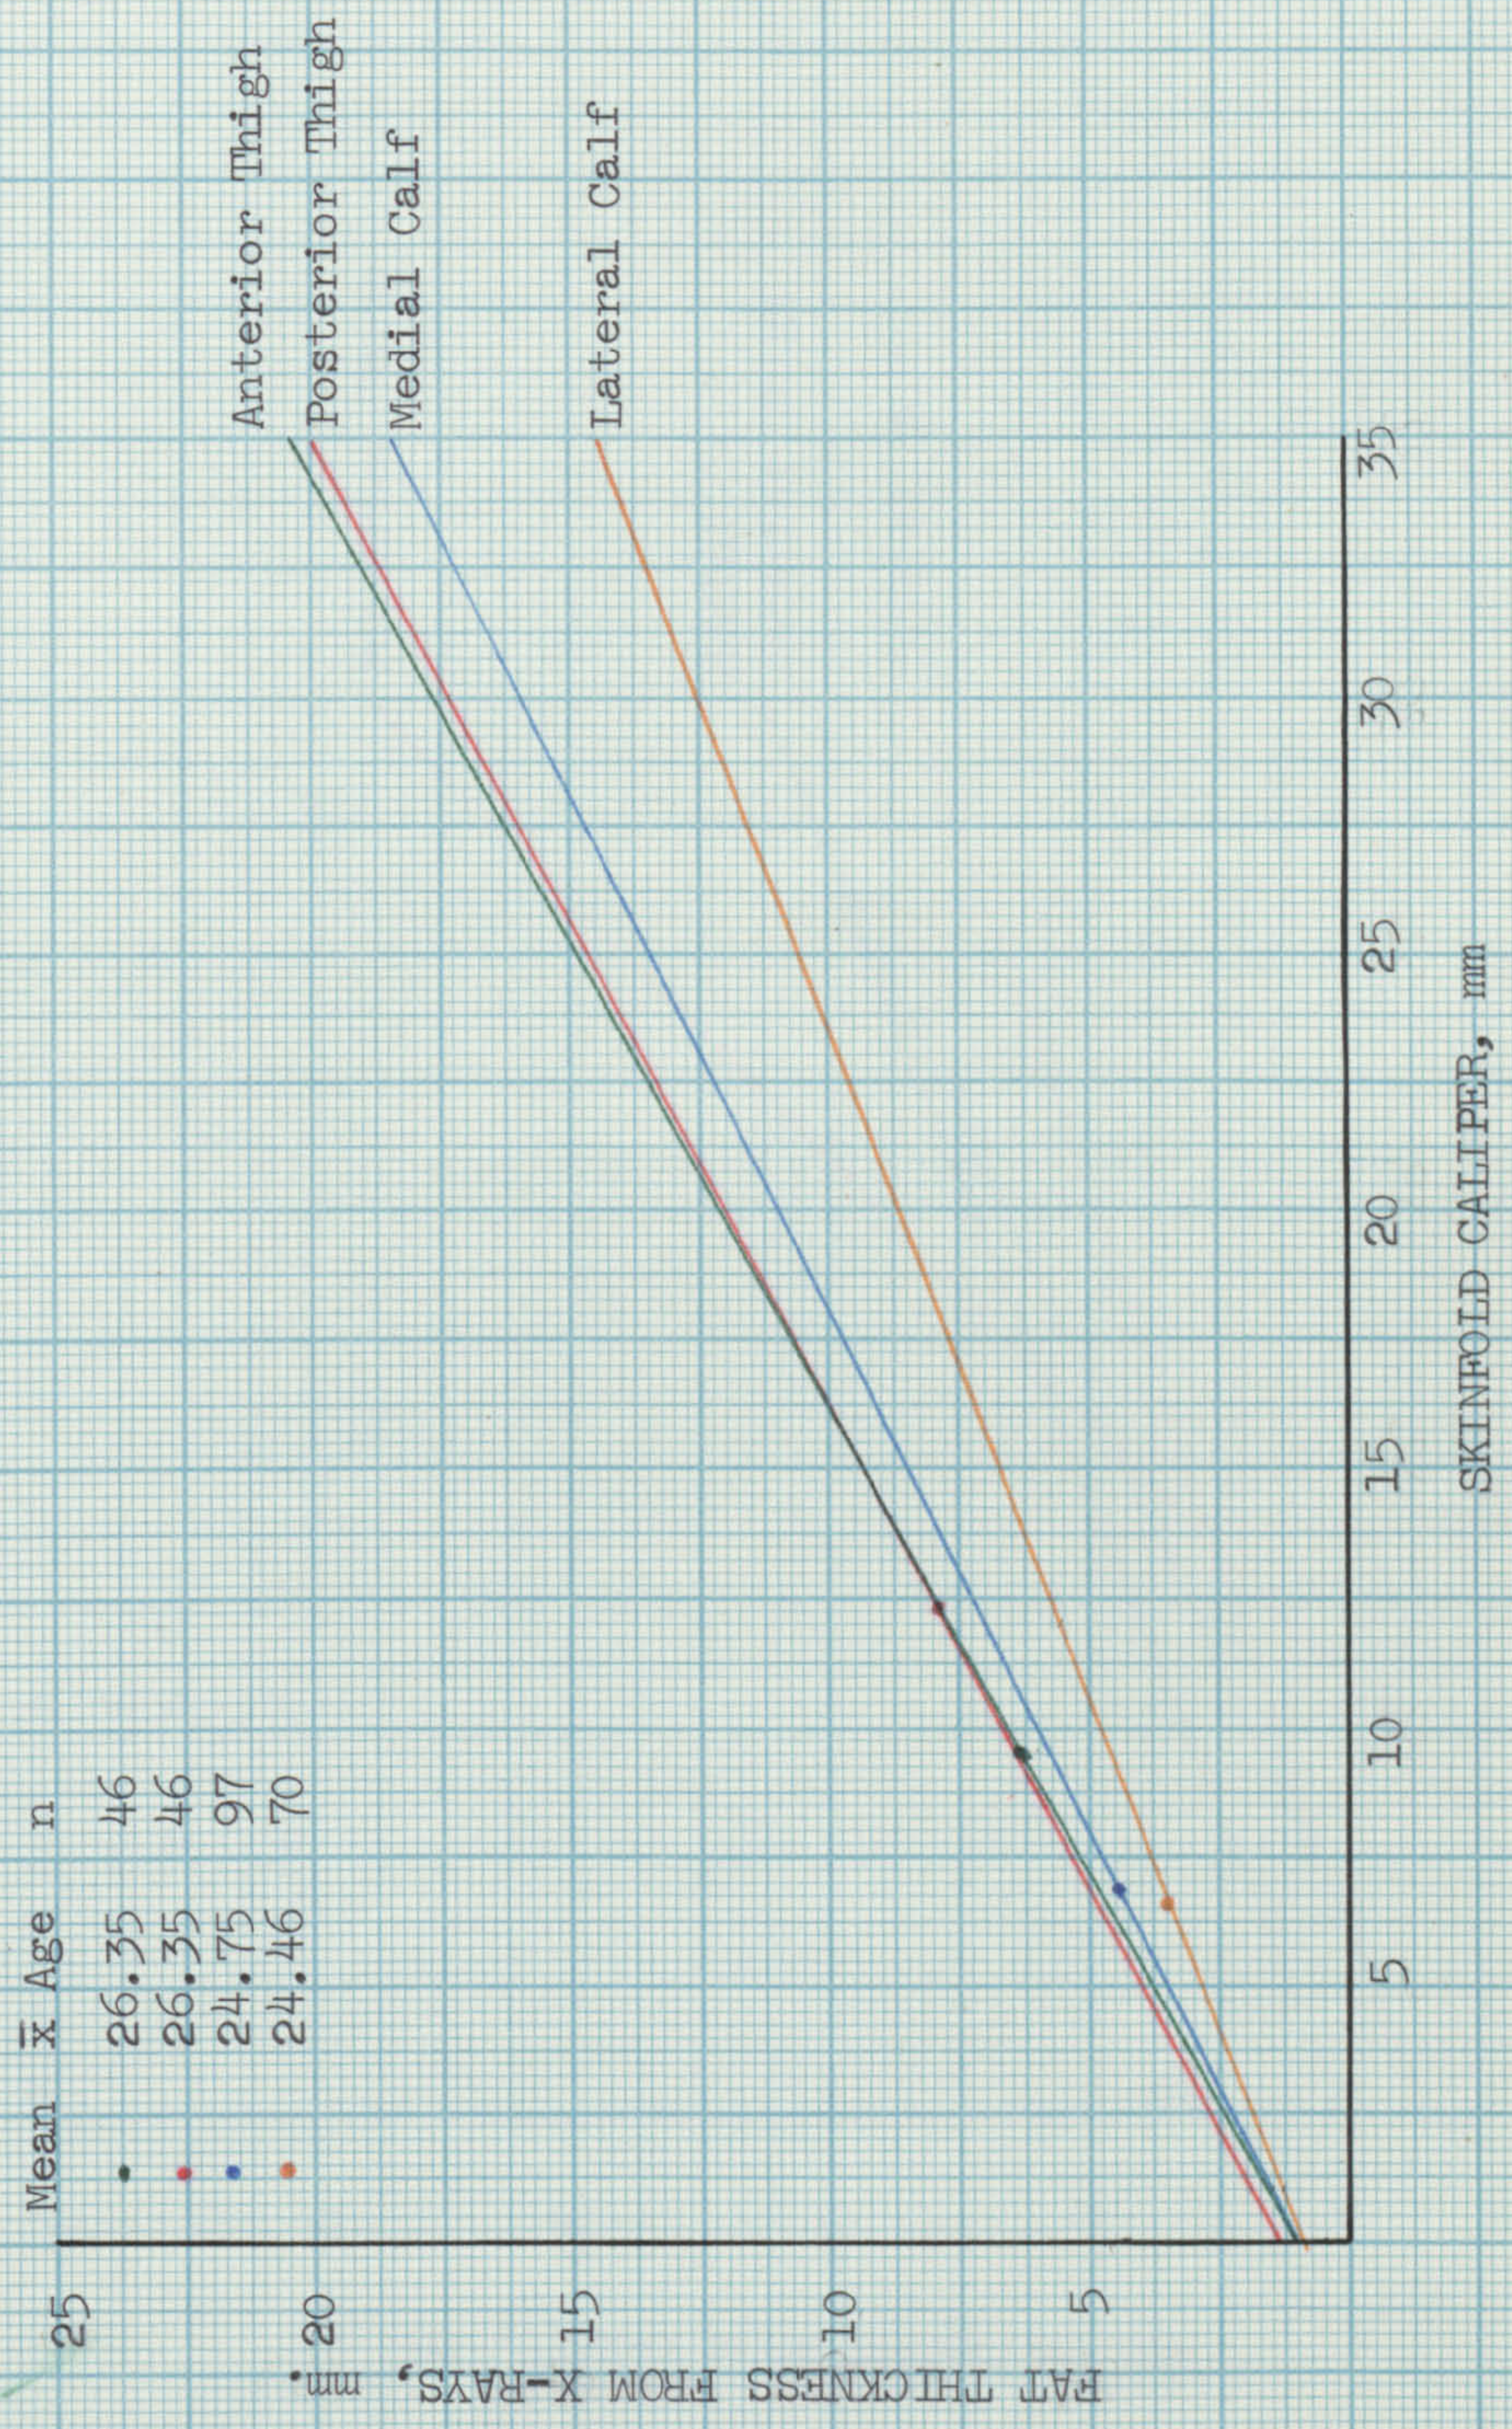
REGRESSION LINES OF FAT THICKNESS BY SOFT-TISSUE ROENTGENOGRAMMETRY ON HARPENDEN SKINFOLD CALIPER READINGS FOR 4 LEG SITES IN YOUNG FEMALES
